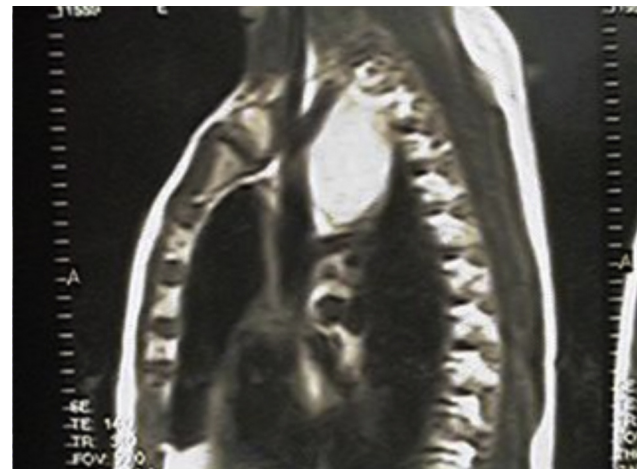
Preoperative MRI of the chest showing an image in the posterosuperior mediastinum.
